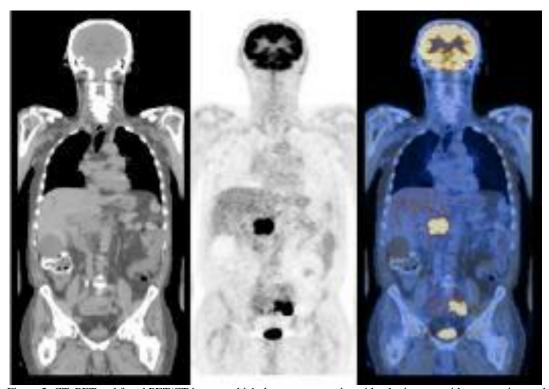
CT, PET and fused PET/CT images which demonstrates a sigmoid colonic mass with metastasis to enlarged retroperitoneal nodes. Given the nodal metastasis, this is at least a stage 3 lesion.
